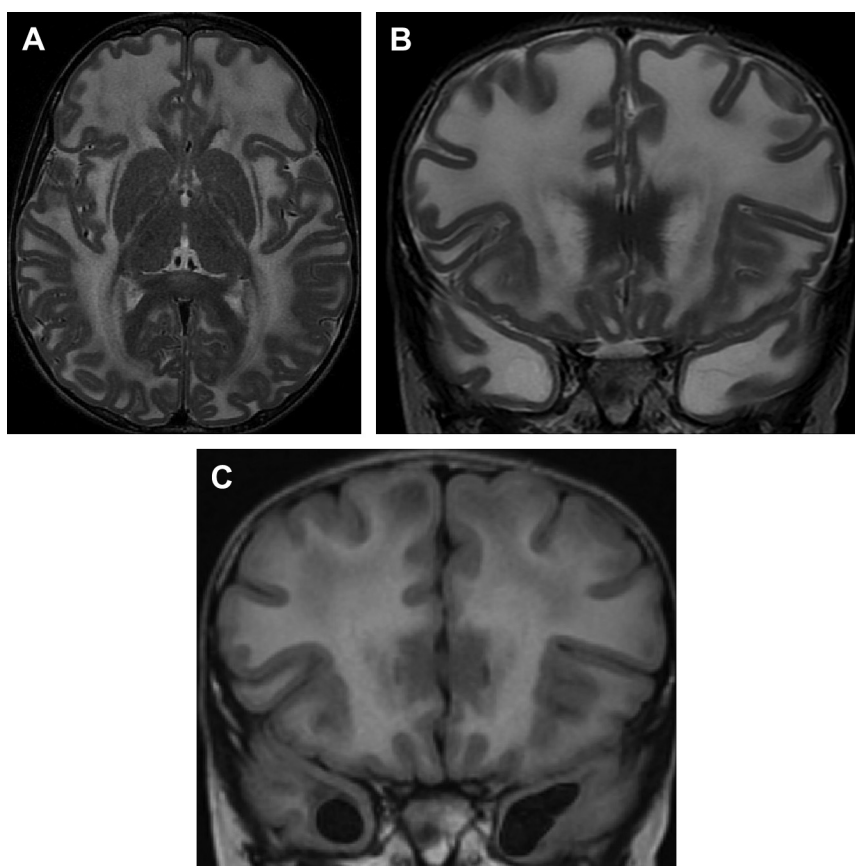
Megalencephalic leukoencephalopathy with cysts in a 3-year-old child with >97th percentile head circumference and frequent falls/imbalance. Notice the expansile white matter signal abnormality greatest in the frontal lobes on the axial and coronal T2-weighted images (A, B). In the temporal lobes there is cystic degeneration best seen on the coronal FLAIR image (C).
